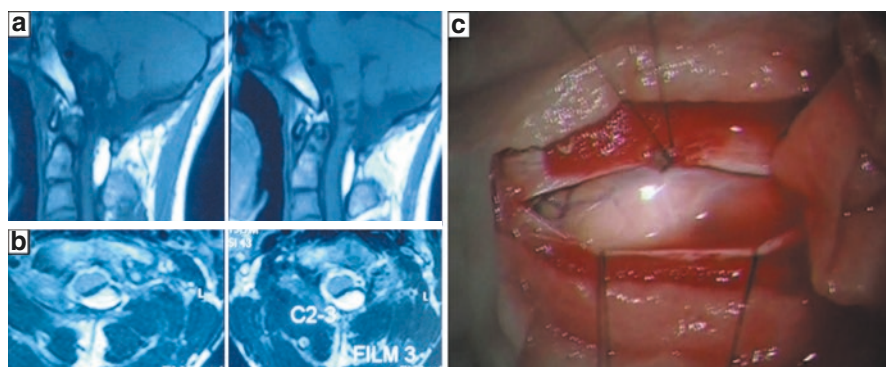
MRI images of a subpial lipoma with morphology after opening of dura at surgery. (a, b): MRI images in sagittal and axial views showing a cervical dorsal subpial lipoma. (c): Morphology of a subpial lipoma after opening the dura
